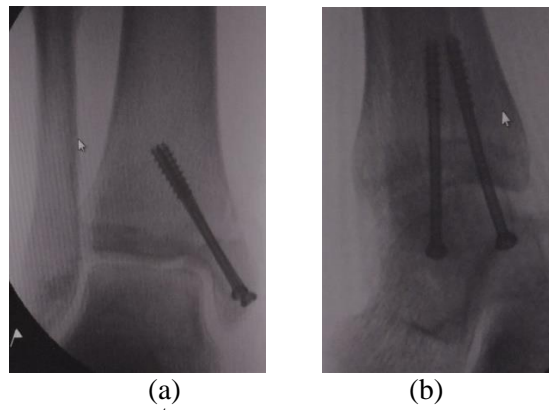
a- AP view of immediate Post-Cast X-ray. , b- Lateral view of immediate Post-Cast X-ray.
